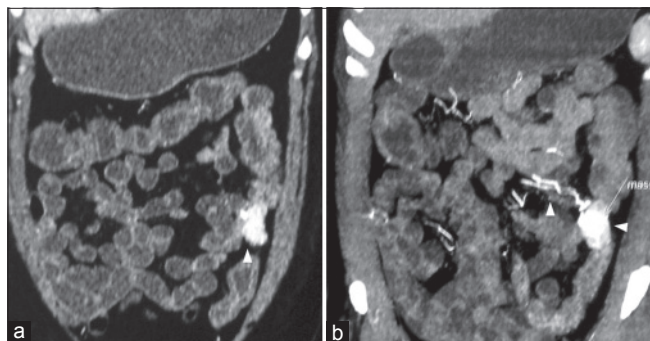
Computed tomography (CT) enterography in a patient of obscure gastrointestinal bleeding (OGIB) showing enhancing mass lesion in ileum with a feeding vessel
